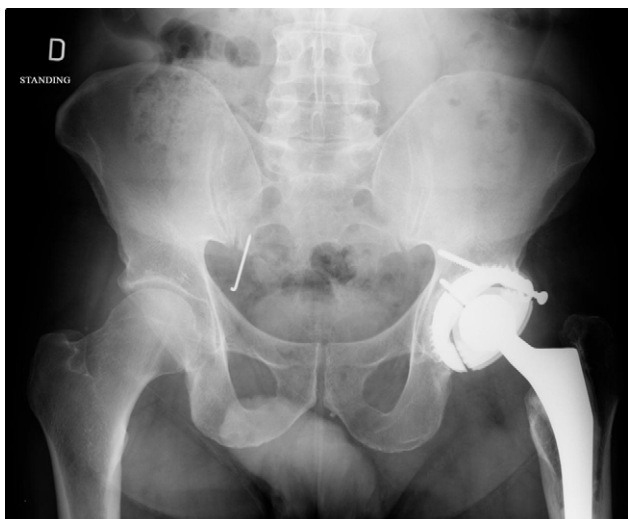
Pelvic X-ray during follow-up of total hip replacement. A K-wire, which had initially been curved, was found in the right pelvic cavity. A. AP pelvic view. B. Strict lateral view. C. Three quarter axillary view.
